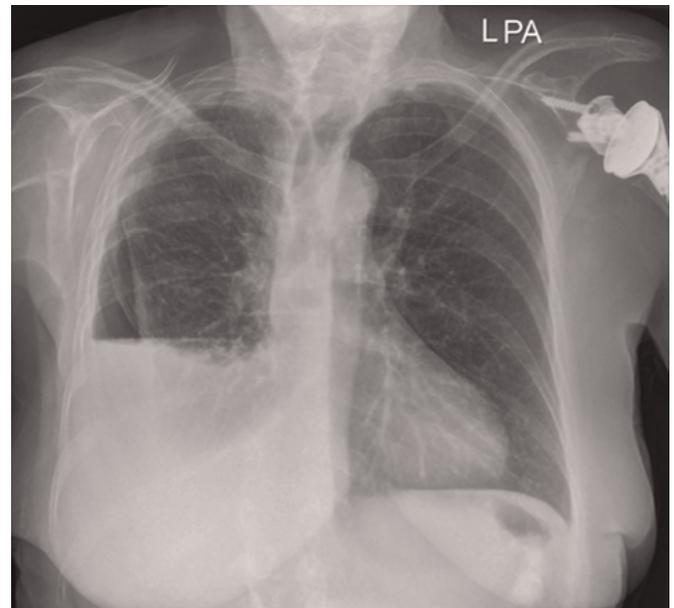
Non-expandable lung on chest radiography with re-accumulation of pleural fluid post-drainage leading to air–fluid level in the pleural space.
